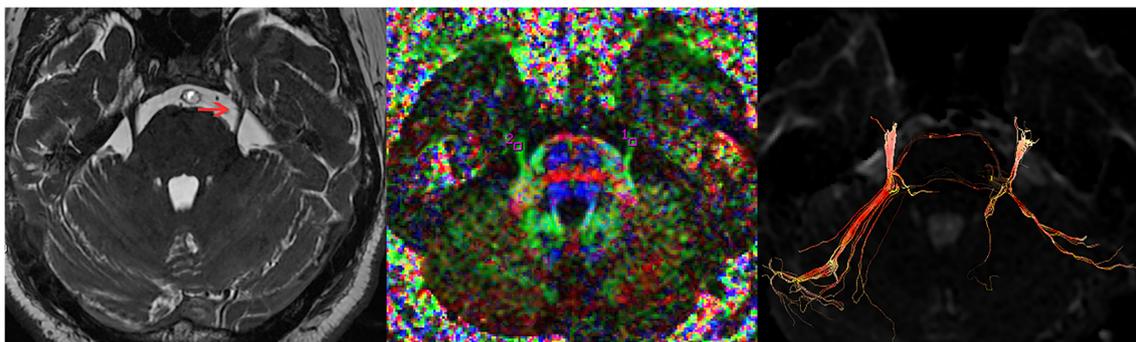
A 56-year-old male TN patient, suffering left maxillofacial pain for more than 2 years. a 3D-FIESTA MRI shows bypass of SCA (arrow) across the cistern segment of the trigeminal nerve. b Regions of interest
